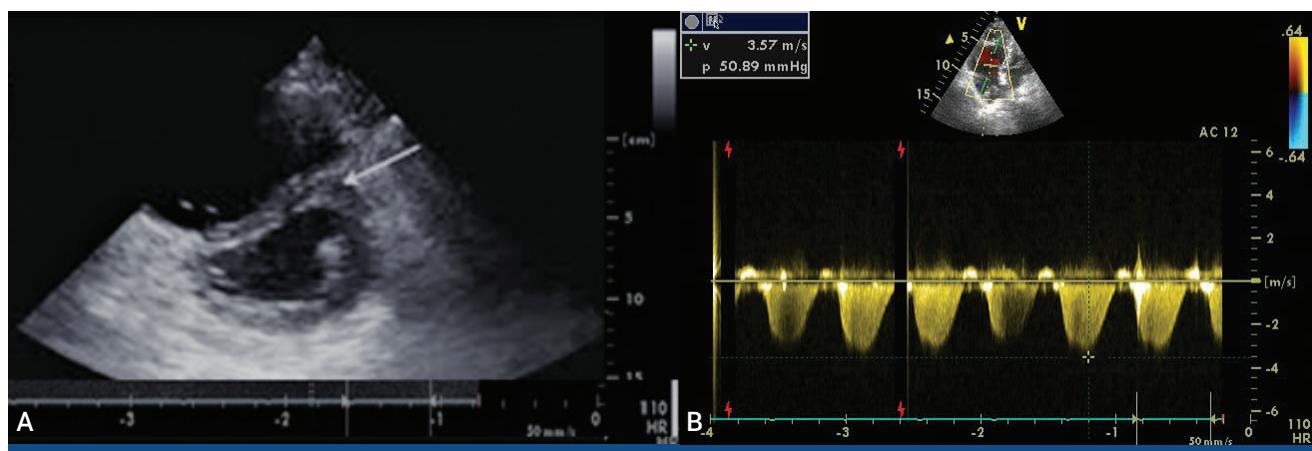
Transthoracic Echocardiography. (A) Parasternal short-axis view of the heart showing a dilated right ventricle with D-shaped left ventricle. (B) Presence of severe tricuspid regurgitation.
